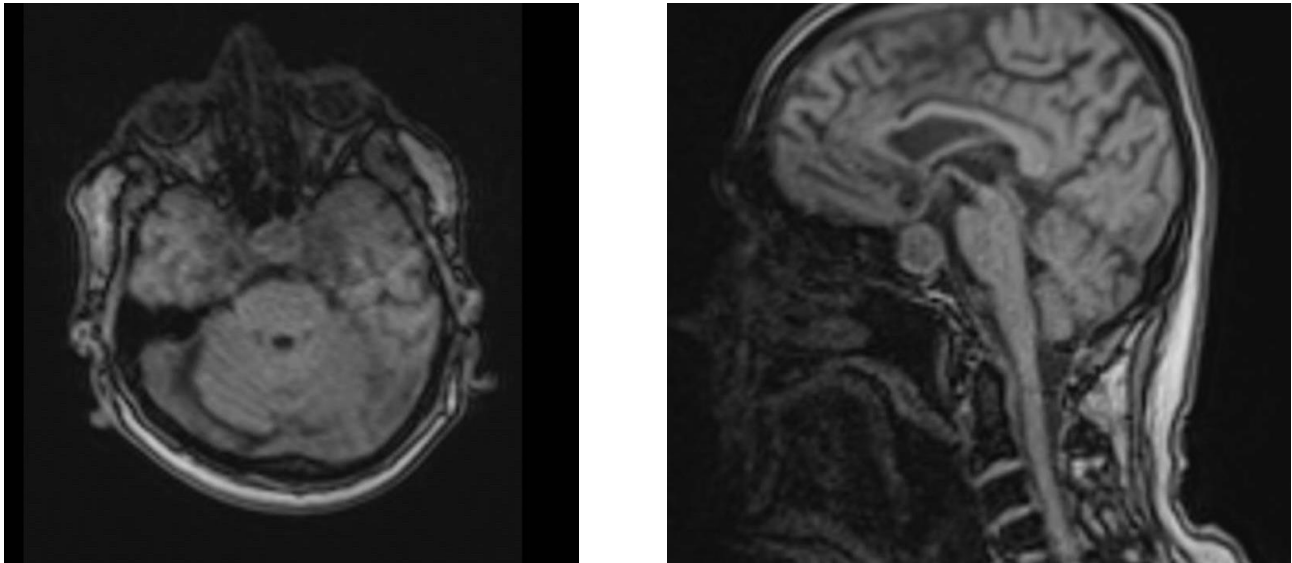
Horizontal (left) and sagittal (right). MRI with contrast showing 20 × 21 × 16 mm sellar mass with subacute blood products. Minor suprasellar extension abuts but does not compress the optic chiasm.
